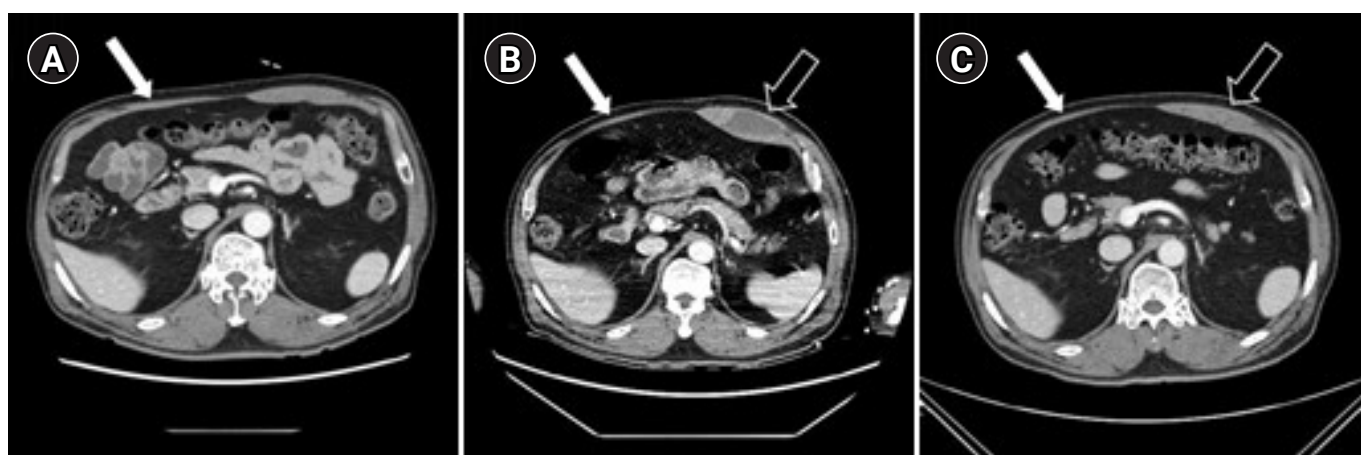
Abdominal computed tomography (CT) findings of the patient on the 38th day (A), 444th day (B), and 468th day (C) after video-assisted thoracoscopic surgery. CT revealed atrophied abdominal muscles (arrows) in the right upper quadrant (A-C) and rectus sheath hematoma (open arrows) in the left upper quadrant (B) at the level of the 11th thoracic vertebra (T11). The size of the hematoma decreased 24 days later (C).
